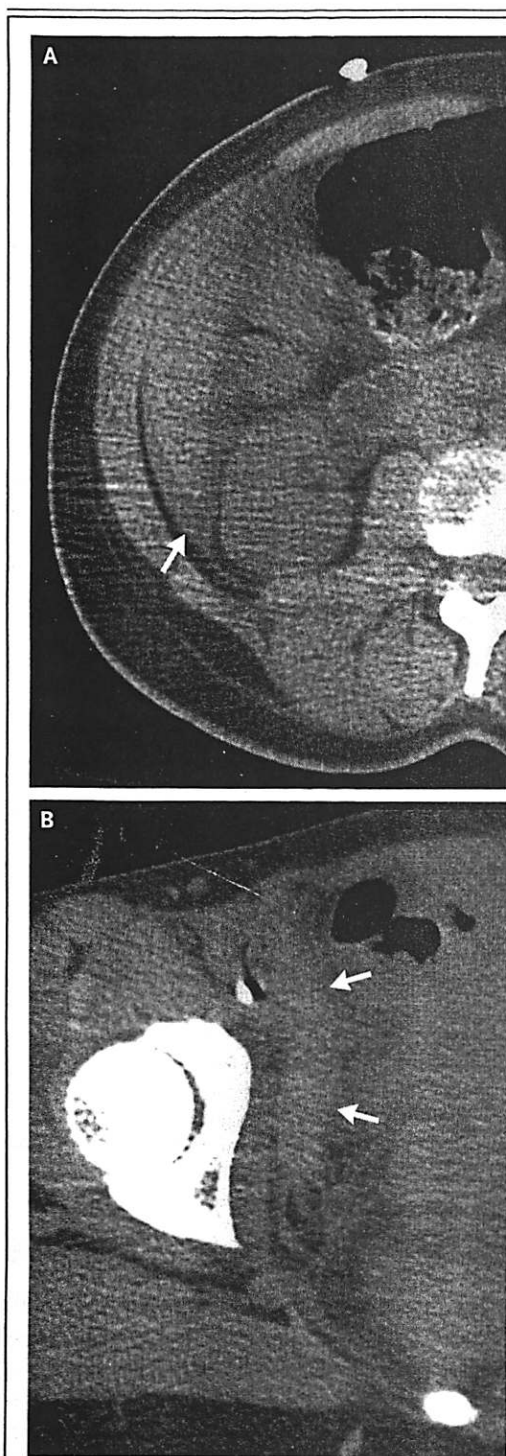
Imaging Studies of the Abdomen and Pelvis. An unenhanced abdominal and pelvic CT scan shows perihepatic ascites (Panel A, arrow) and a band of hyperattenuating soft-tissue density (Panel B, arrows) adjacent to a right femoral catheter, features that are consistent with a hematoma.
